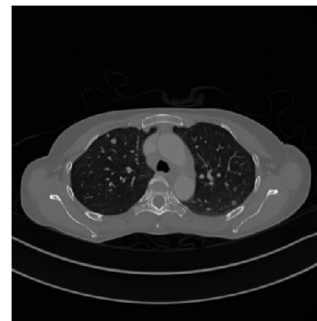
Result of Threshold Value in CT Image Preprocessing
